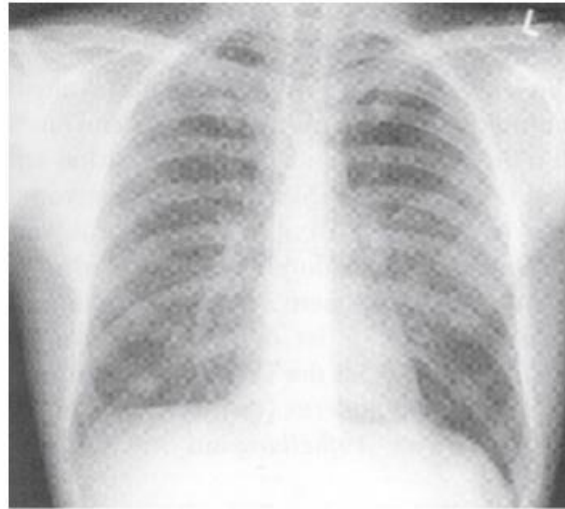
Chest X-ray image.
